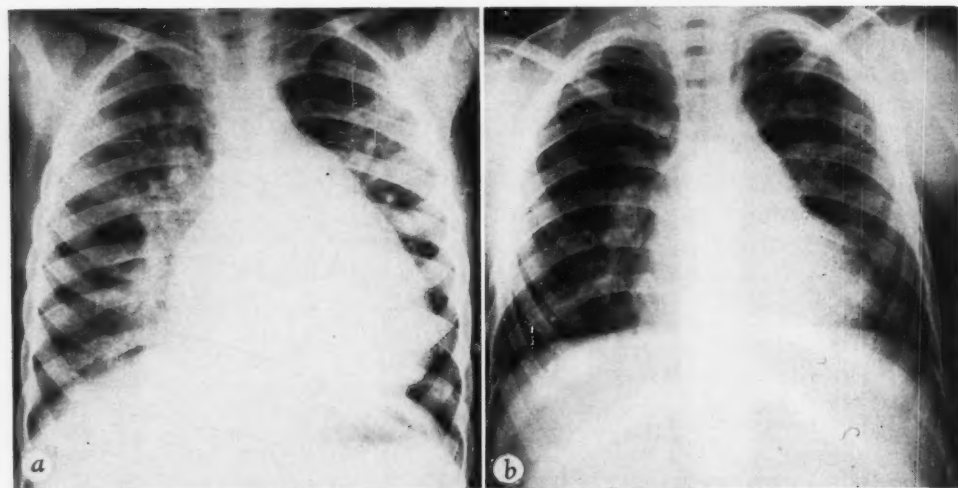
Preoperative and postoperative roentgenograms of the chest of a 5 year old boy who had repair of an atrial septal defect followed in 3 months by repair of a concomitant coarctation of the aorta. The first roentgenogram was taken two weeks before the atrial septal defect was repaired. The second roentgenogram was taken 6 months after the correction of the coarctation. The two films were taken about nine and a half months apart.
